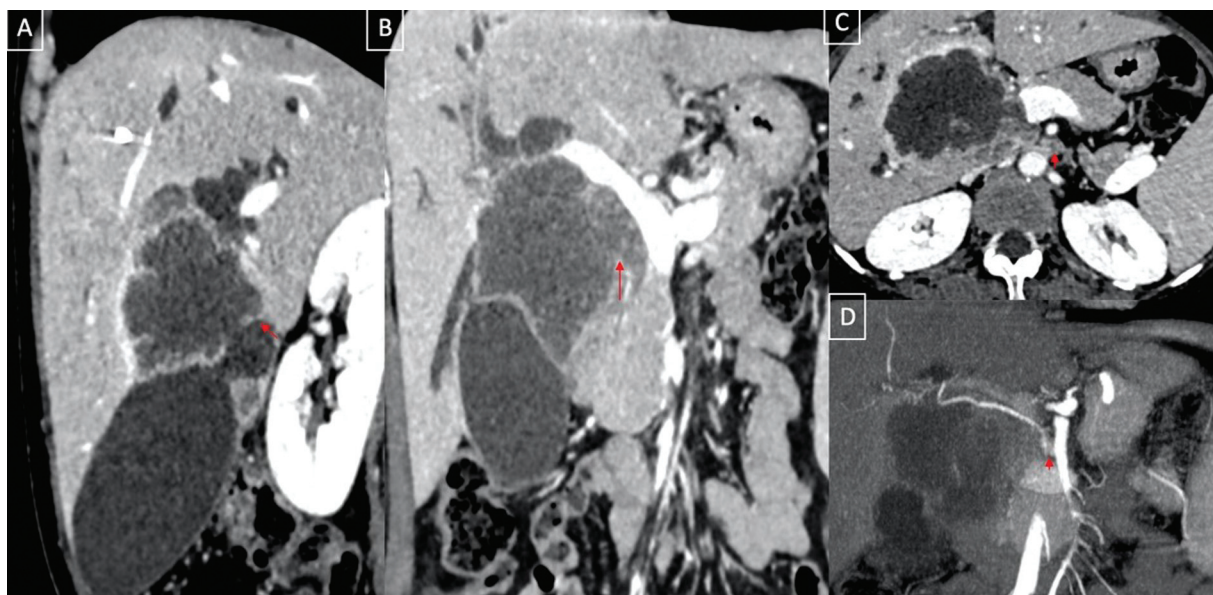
A 42-year-old with combined type of gallbladder cancer. Sagittal (A) and coronal (B) reformatted contrast-enhanced computed tomography images show the asymmetrical mural thickening involving the body and neck of gallbladder with a peripherally enhancing mass in contiguity with the thickening extending into the adjacent liver parenchyma. Note the necrotic periportal lymph nodes (arrow, C) and replaced right hepatic artery encased within the mass (D). Depiction of the exact locoregional extent including the vascular anatomy is crucial for surgical planning and staging of the disease which is well depicted with contrast-enhanced computed tomography and its multiplanar capabilities.
